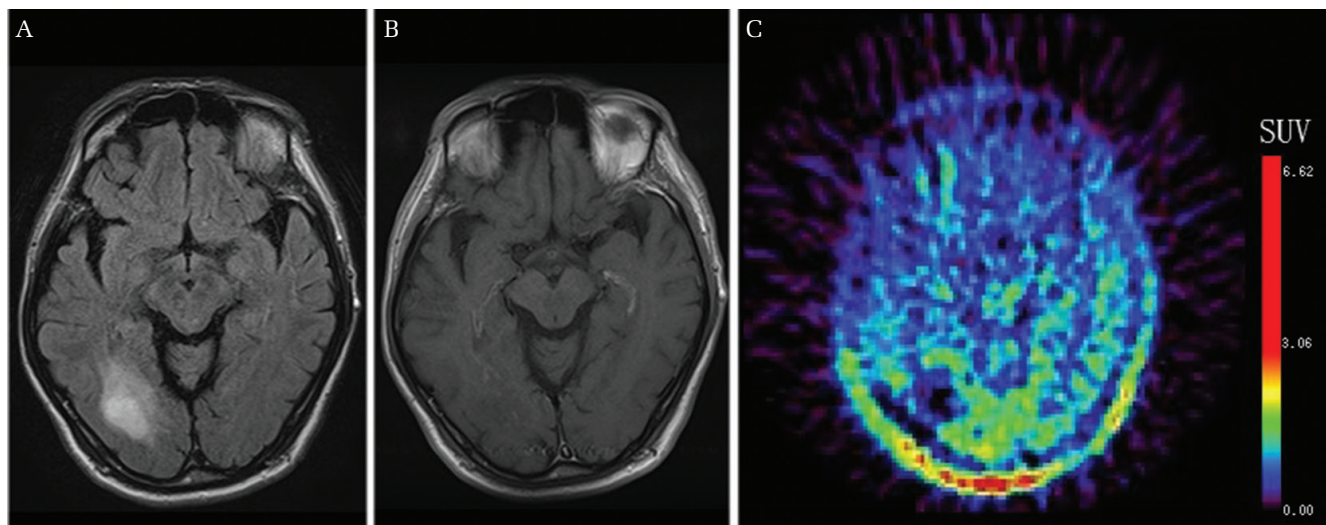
Preoperative imaging results of representative case 1. (A) Fluid-attenuated inversion recovery image showing perifocal edema. (B) Gadolinium-enhanced magnetic resonance image showing a ring-enhanced lesion in the subcortex of the right frontotemporal lobe. (C) [ $^{11}\text{C}$ ] methionine (MET) positron emission tomography imaging. The tumefactive lesion shows high uptake of [ $^{11}\text{C}$ ] MET (L mean/N ratio = 1.77 and L max/N ratio = 2.63).
